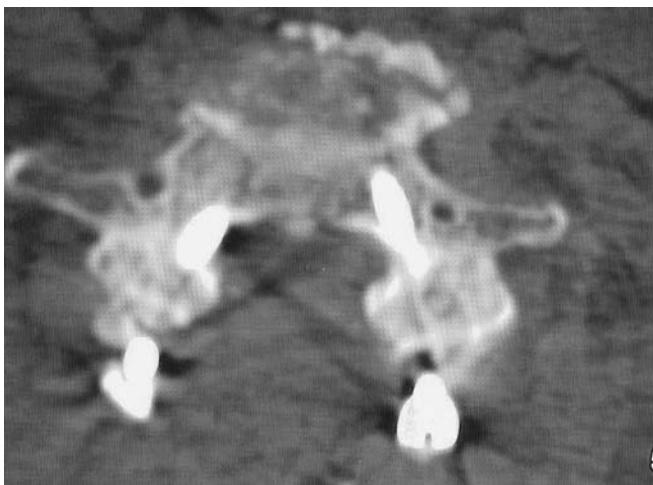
Postoperative CT scan appearance of C7 pedicle screw encroaching on right lateral recess.
